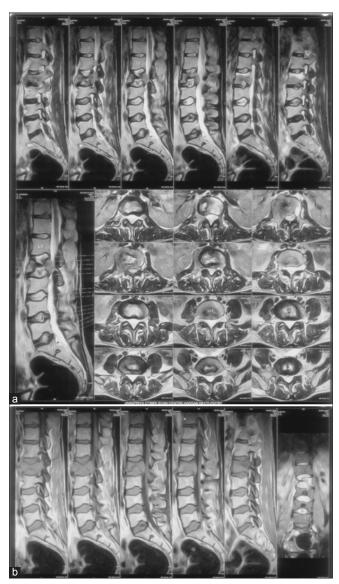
(a) MRI T2 image showing vertebral body collapse and thecal sac compression. (b) MRIT1 image showing vertebral collapse
